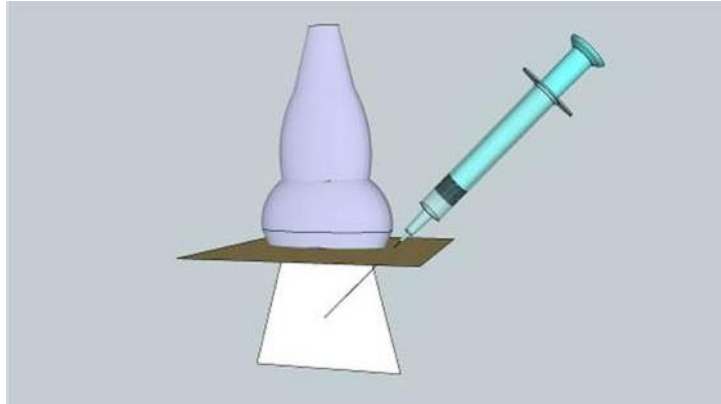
Inplane approach of ultrasonography
